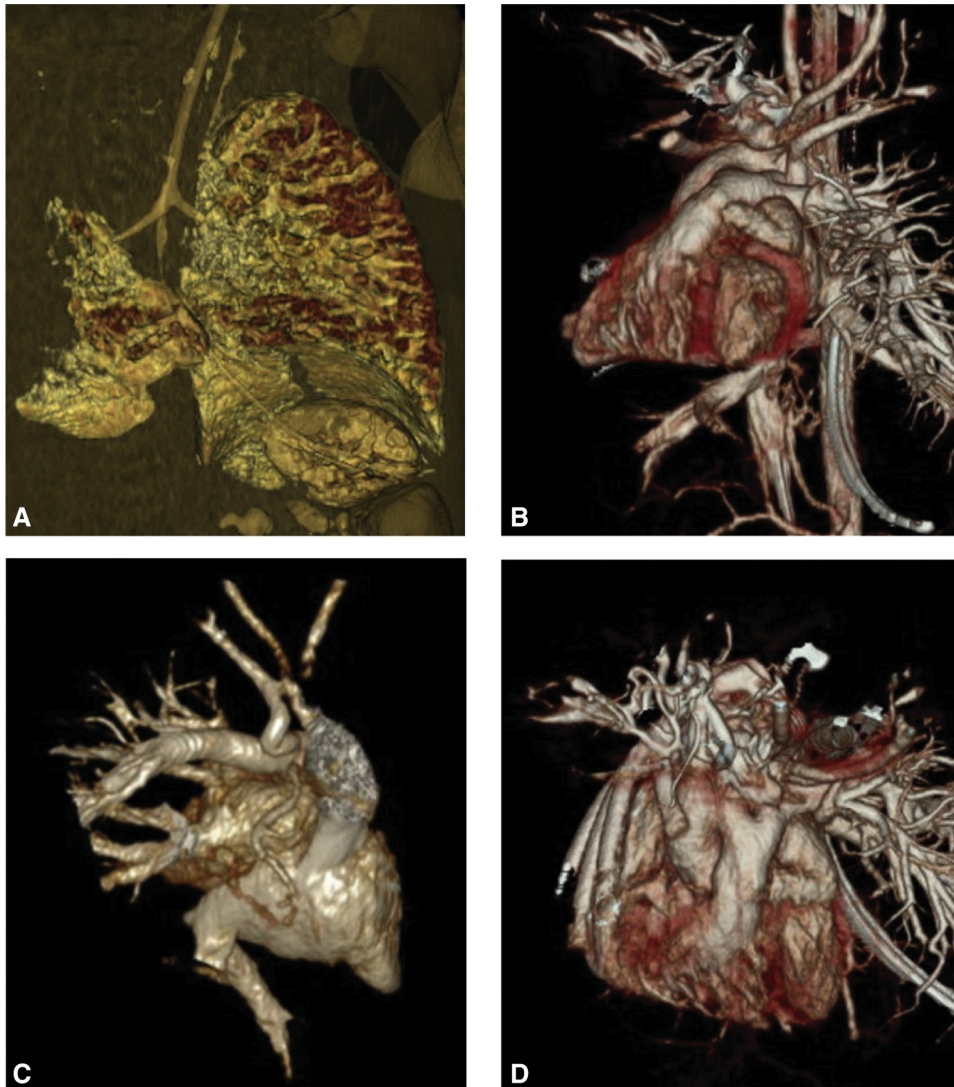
Three-dimensional (3D) computed tomography reconstruction. 3D reconstruction of computed tomography provided visualization of (A) hypoplasia of the right lung, as well as (B-D) right-sided aortic arch, isolated left subclavian artery arising from left pulmonary artery, and spatial relationships of surrounding structures.
